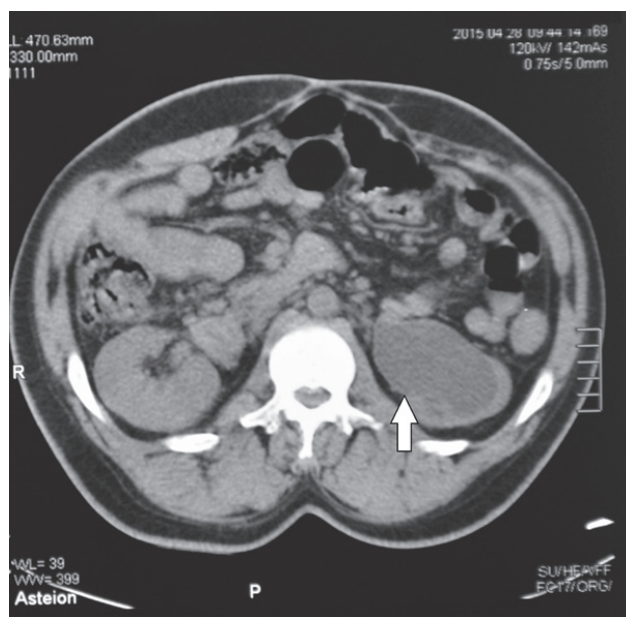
CT abdomen. Hydronephrosis of the left kidney due to pelviureteric junction obstruction (arrow).
